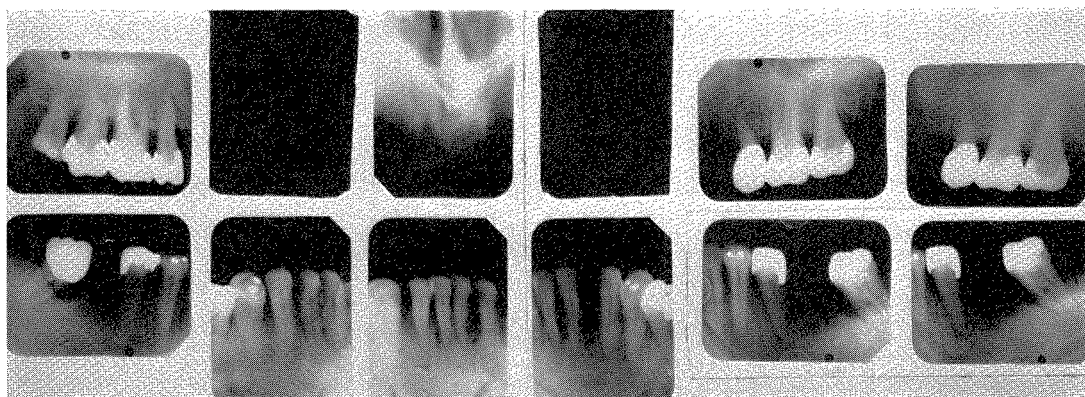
The roentgenograms that were taken in July, 1947, after the rehabilitation was completed are shown here.
